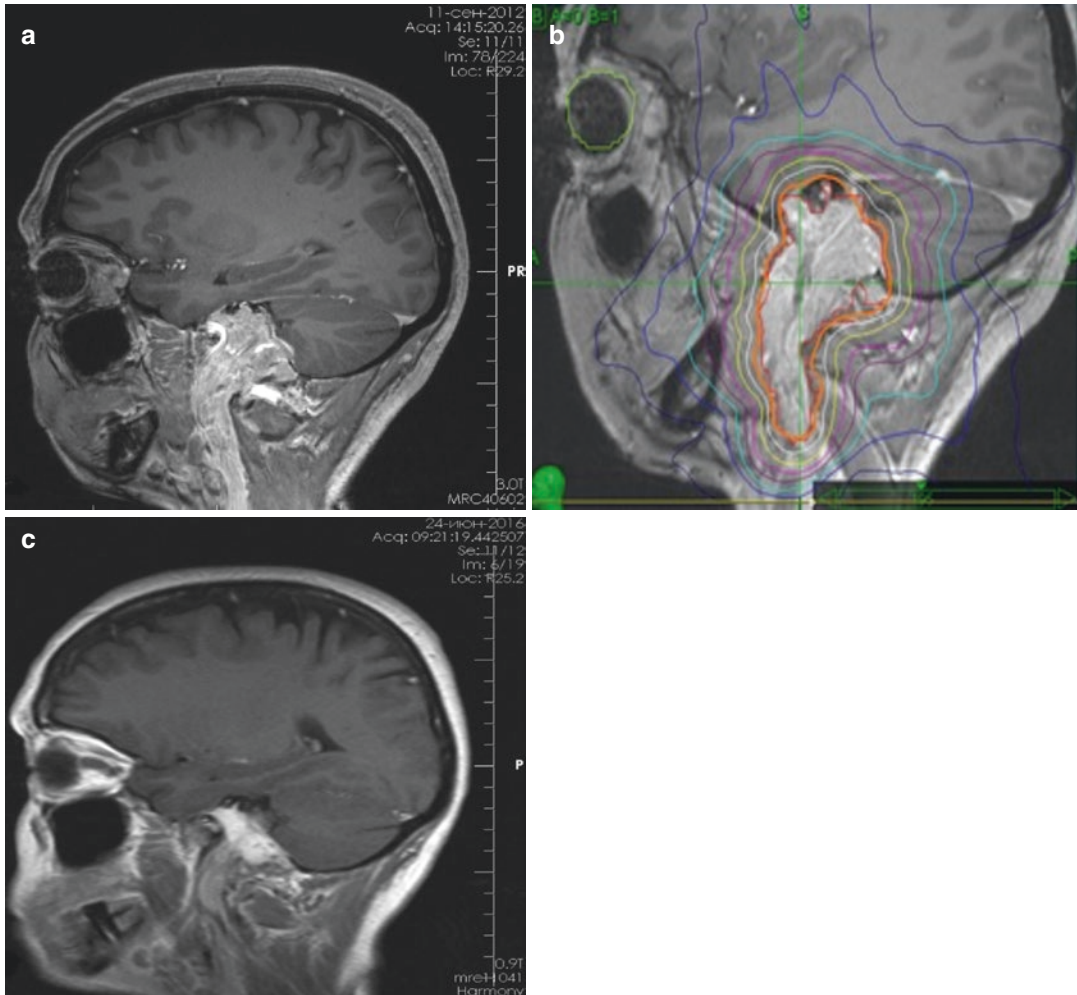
(a) Pre-treatment MRI of a jugulotympanic paragangliomas with a pronounced extracranial extension (tumor volume was 17.8 cm³). (b) CyberKnife treatment plan (five fractions per 6 Gy). Prescribed dose was 27 Gy
